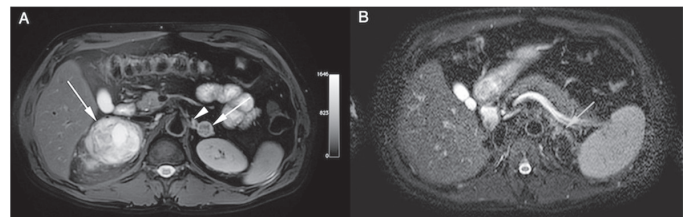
Magnetic resonance image of the postoperative bilateral adrenal mass. B. Postoperative magnetic resonance image
